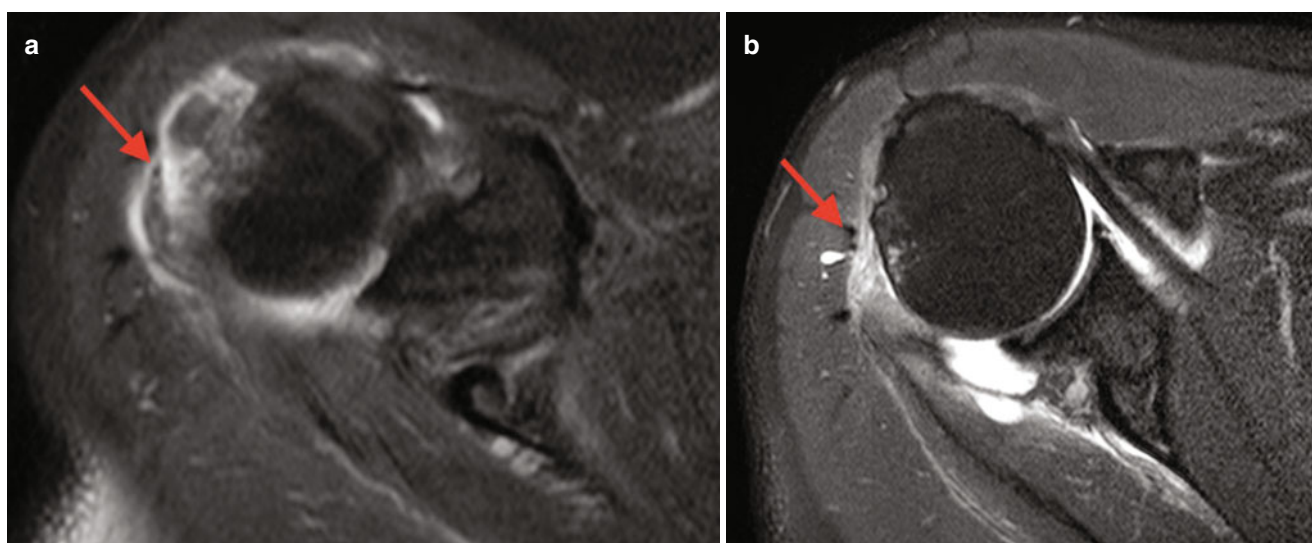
MRI showing complete lesion of the infraspinatus tendon with retraction (*red arrow*). (a) Lesion at tendon's insertion; (b) retraction of the tendinous belly (*red arrow*)
